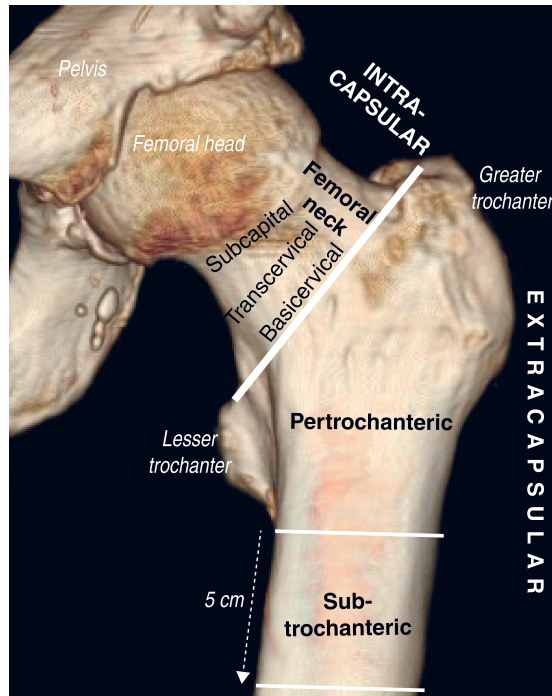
Classification of hip fracture according to anatomical site. The reconstruction of the computed tomography was obtained from the database of the Foundation of Estonian PACS (Picture Archiving and Communication System).
